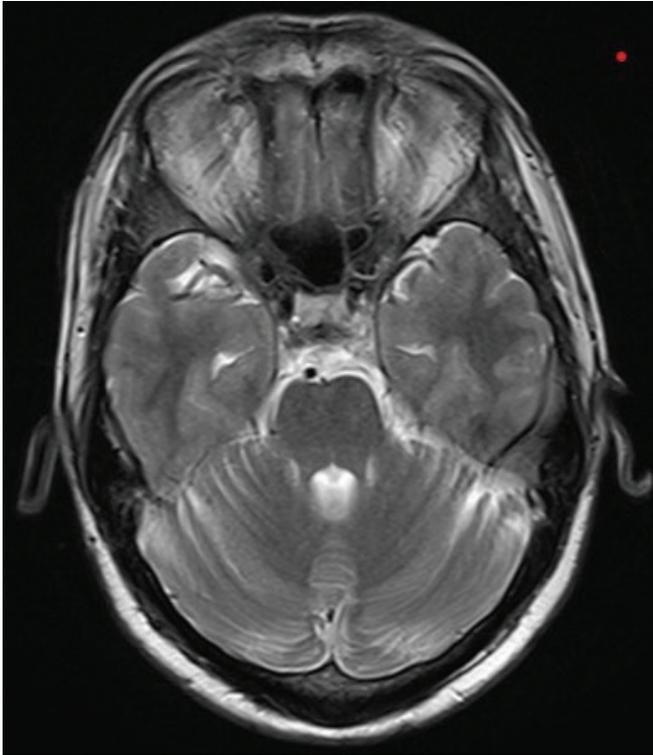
Magnetic resonance imaging of the patient showing normal parenchyma at the pontine level.
